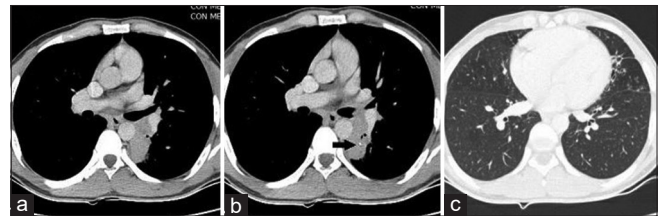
Contrast-enhanced computed tomography of chest: (a) transverse section mediastinal window at the level of carina, (b) transverse section mediastinal window at the level of the left and right main bronchus, (c) transverse section lung window showing lingular lobe
